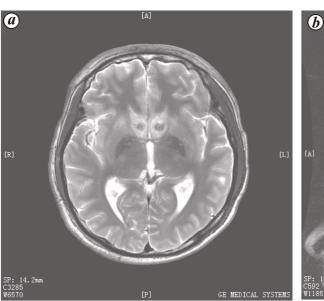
The axial view MRI (a) and sagittal view MRI (b) of the patients after surgery.
